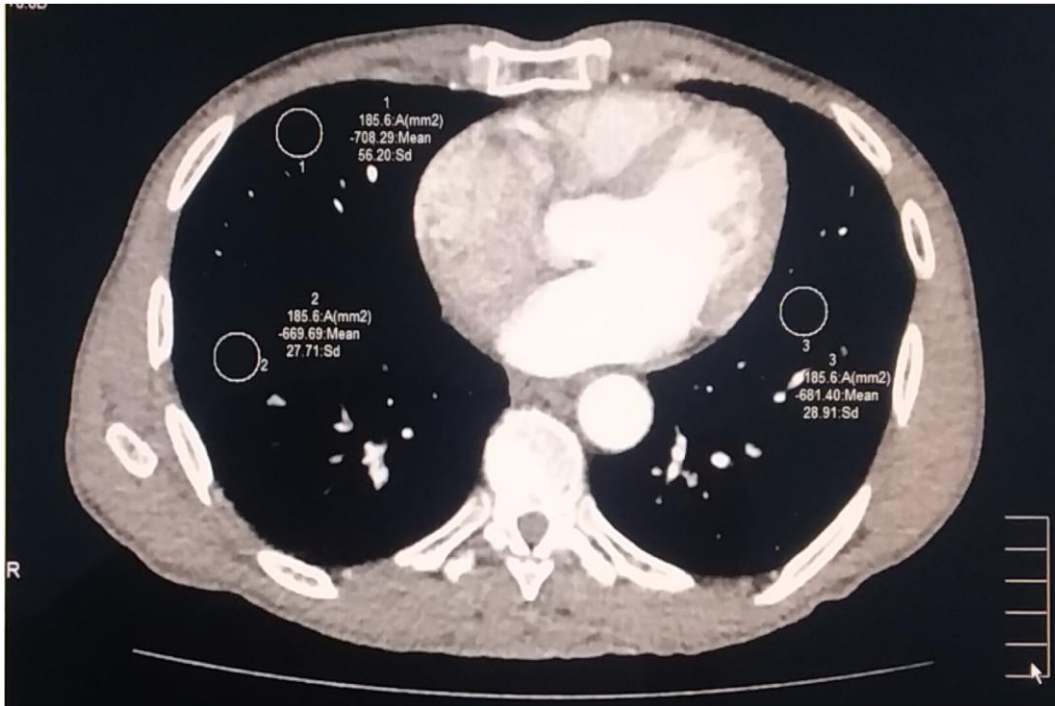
Measurements of noise in CT image for lung during low dose imaging protocols (120 kVp, 40 mAs, rotation time 0.5 s and helical pitch 65).
